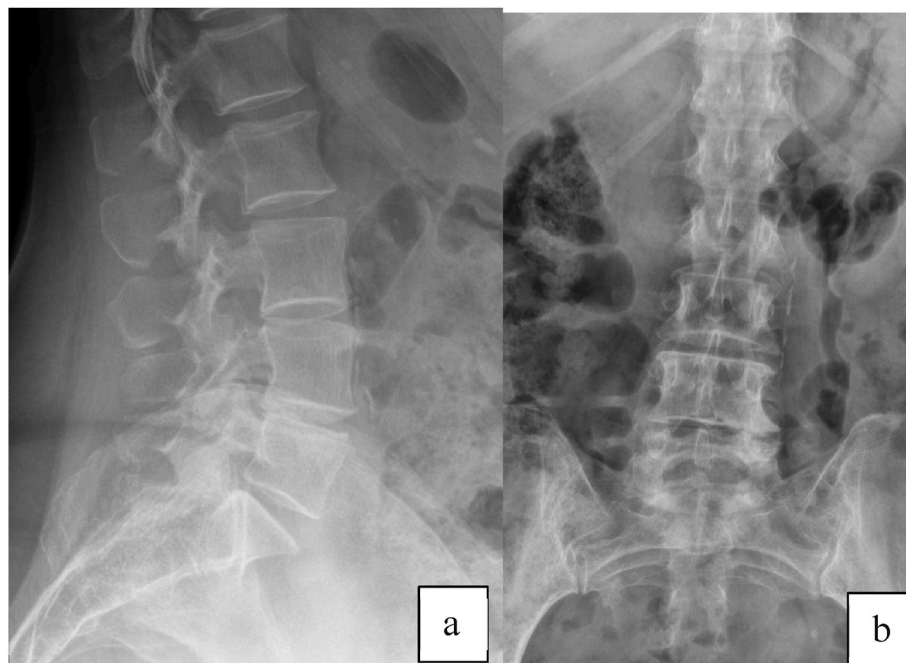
Preoperative X-rays.
